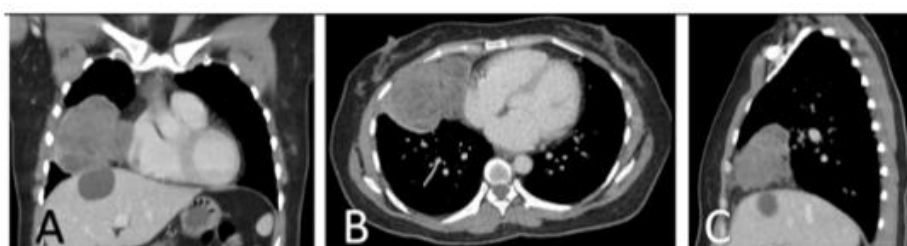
(Preoperative CT Thorax images) Demonstrating well-defined, lobulated, and encapsulated heterogeneously enhancing mass 5.5 x 9.2 x 8.8cm (AP x W x CC) with irregular border seen at the right anterior aspect of mediastinum with local infiltration. A: Coronal view. B: Axial view. C: Sagittal view.
